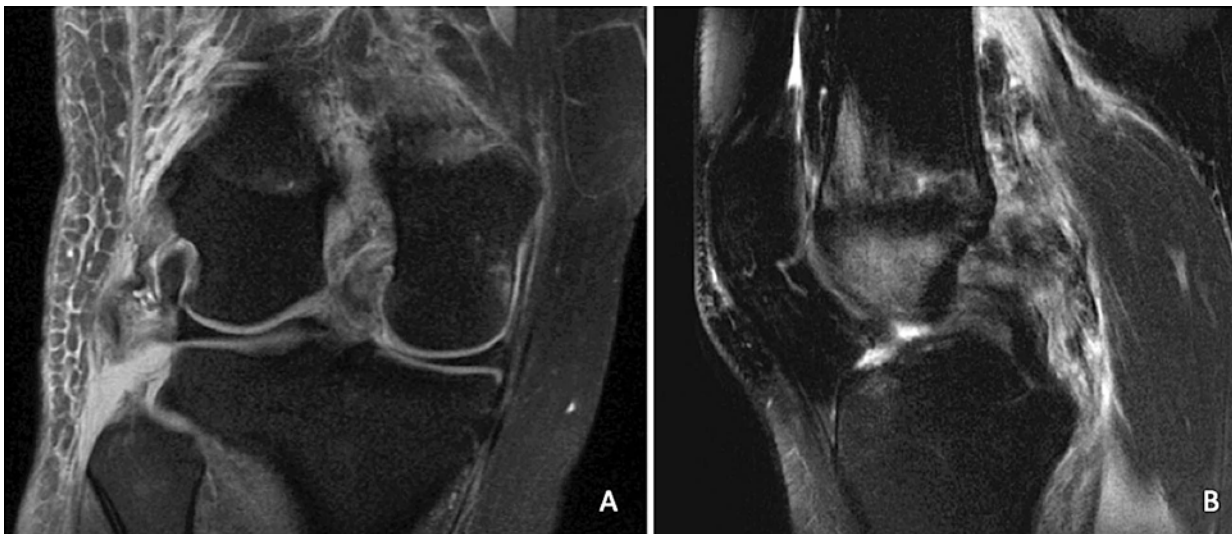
Selected coronal PD FS (A) and sagittal T2 FS (B) MRI images demonstrating a distal avulsion of the LCL from the fibular head, a complete ACL tear, and an incomplete PCL injury
